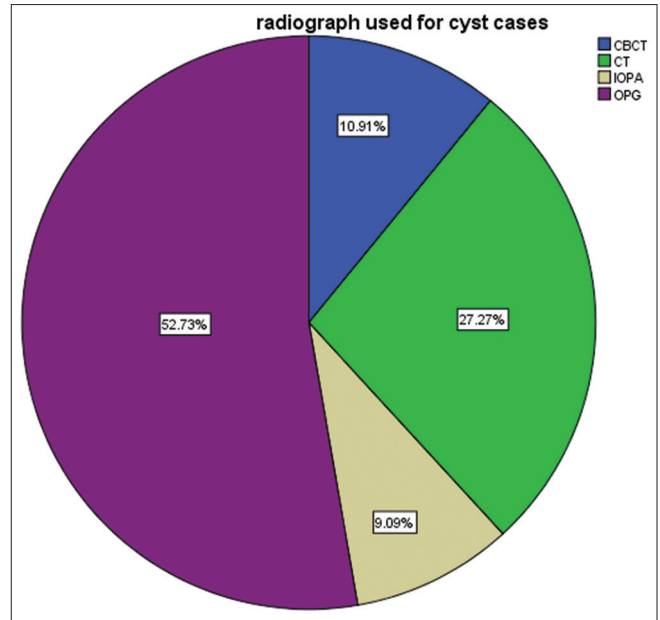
The radiographs used for cyst cases
